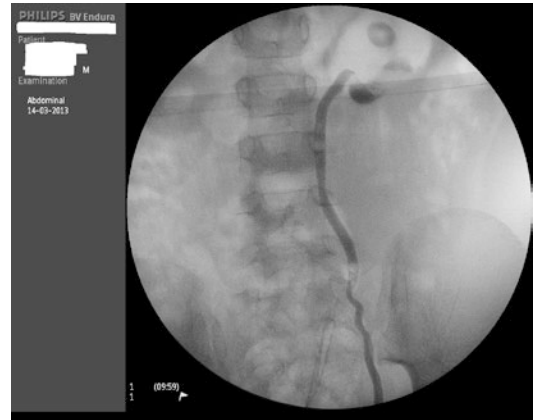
(a) Ultrasound scan showing PCS dilatation which settled on conservative management and thus discharged, (b) Same patient presented 3 days later with acute obstruction and pain
